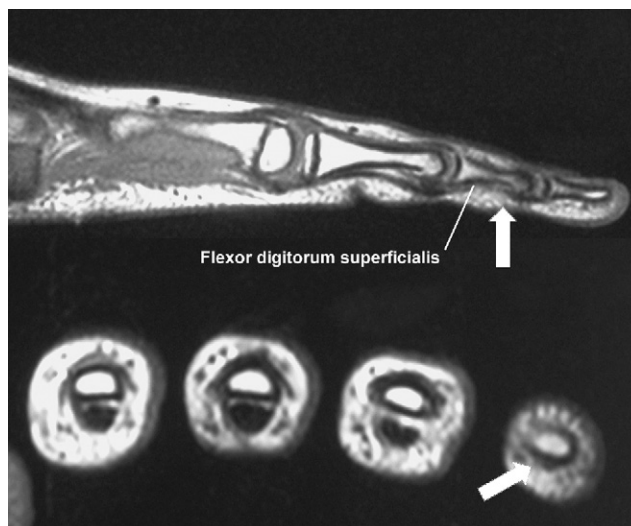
MRI of the small finger; the arrows indicate the missing deep flexor tendon. Authors:
